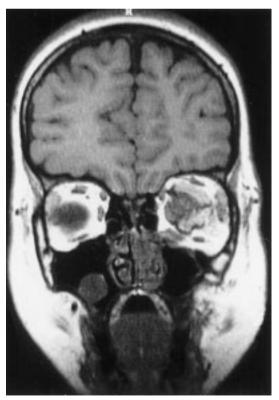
MRI-T₁ coronal: intraorbital lymphangioma.
